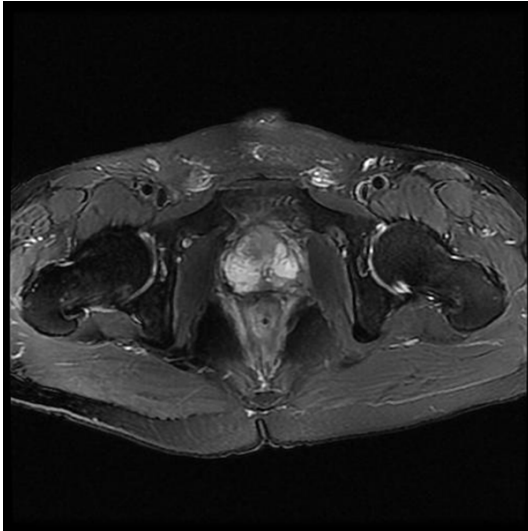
MRI FIG of seminal vesicles mucinous carcinoma. T2-weighted image showed bilateral seminal vesicles area had high signal change.
